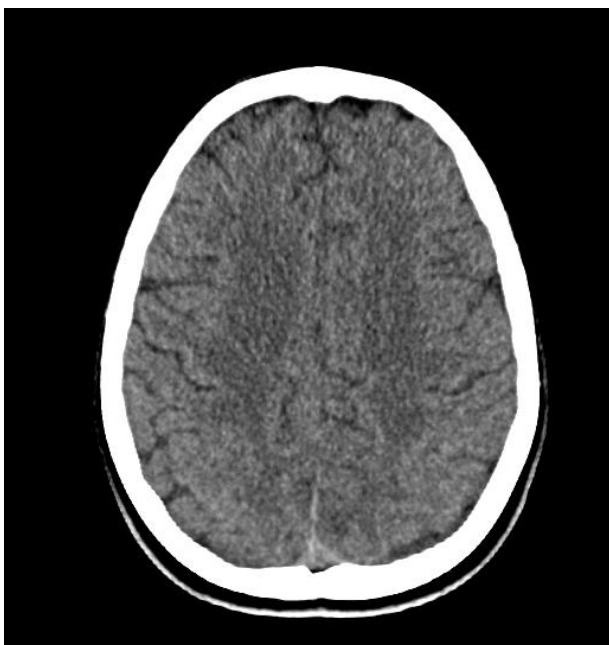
Axial view non-contrasted CT Brain (reprinted with permission of the patient)
